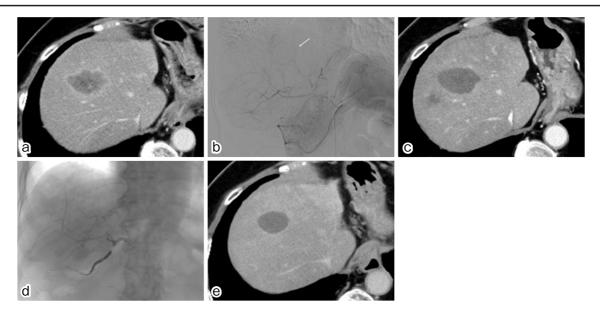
Case 1: A 79-year-old woman with liver metastases from colorectal cancer. (a) CE-CT before DEBIRI-TACE showed liver metastasis in the liver segment 8. In addition to this lesion, multiple small metastases were found in the right lobe.
